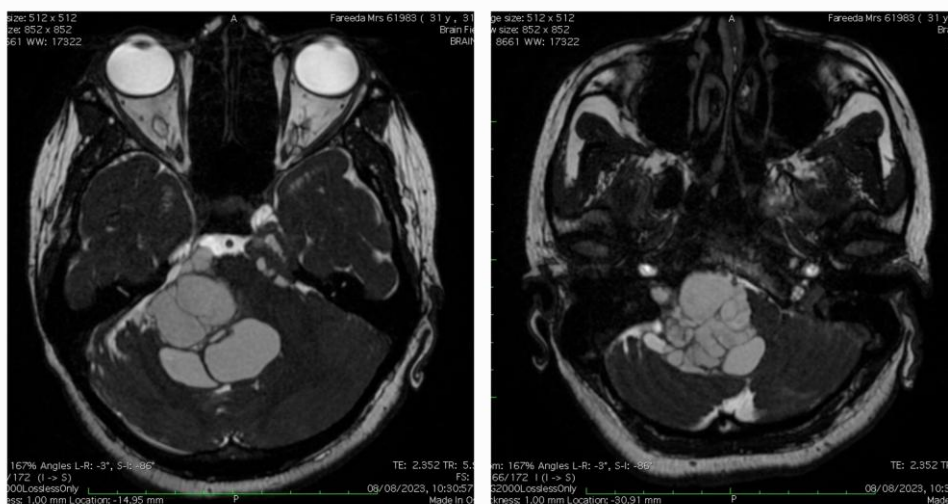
MRI brain showing cystic lobulated mass in right prepontine and cerebellomedullary cisterns with infiltration into right hypoglossal canal
